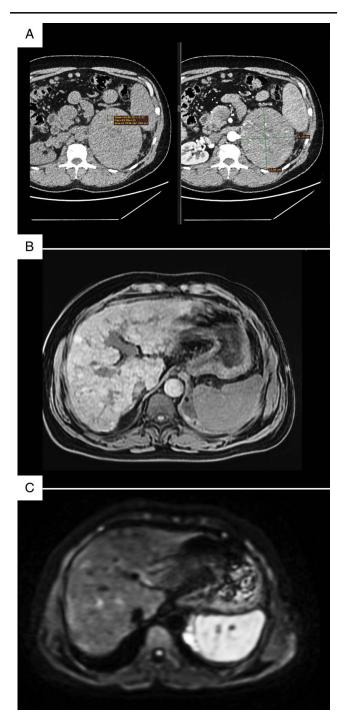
(A) Pre-contrast and arterial phase showing size, density and washout characteristics of adrenal lesion. (B) MRI showing multiple liver lesions hyperintense on T1. (C) Diffusion-weighted imaging showing no diffusion restriction.
